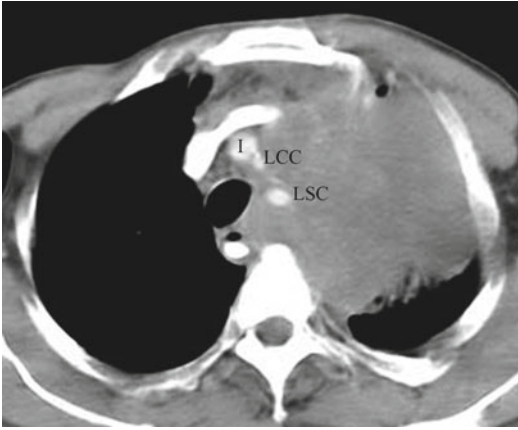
T4 lesion. Axial CT reveals large left upper mass with invasion into the mediastinum and encasement of the innominate artery (I), left common carotid artery (LCC), and left subclavian artery (LSC)
